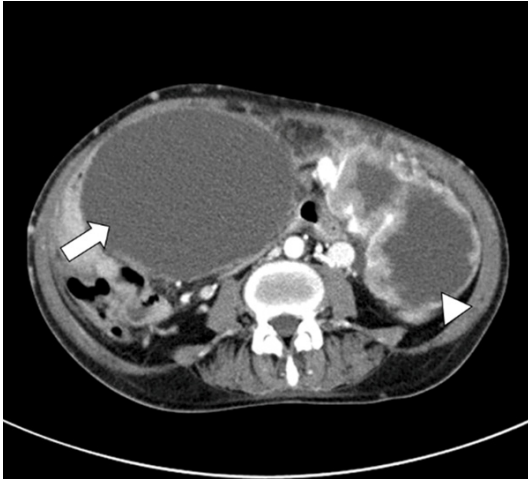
Contrast-enhanced computed tomography scan showing 16 cm (arrow) and 12 cm (arrowhead) sized cystic and solid ovarian masses with enhanced solid tissue components.
